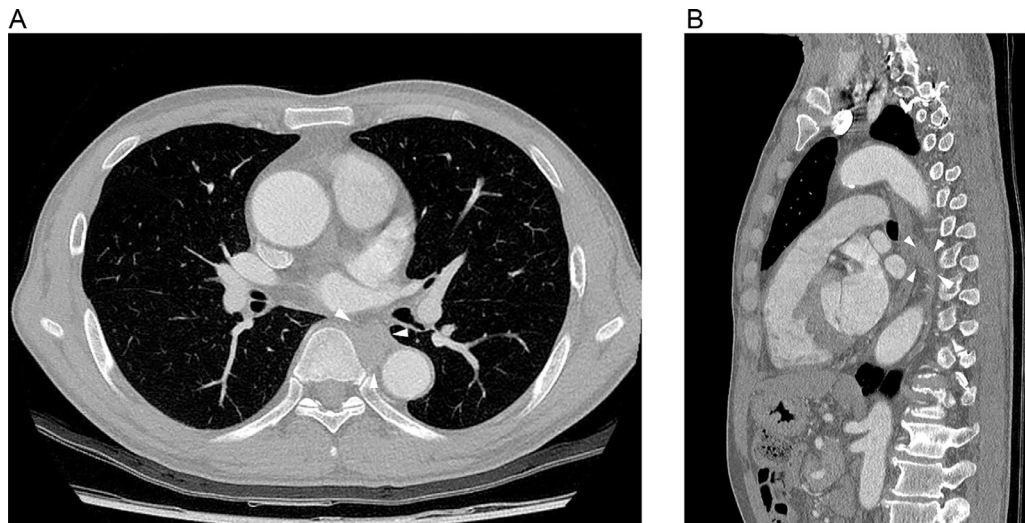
A contrast-enhanced chest CT scan. A soft tissue lesion (arrow heads) in the Lt. paraspinal area (T8 level).
